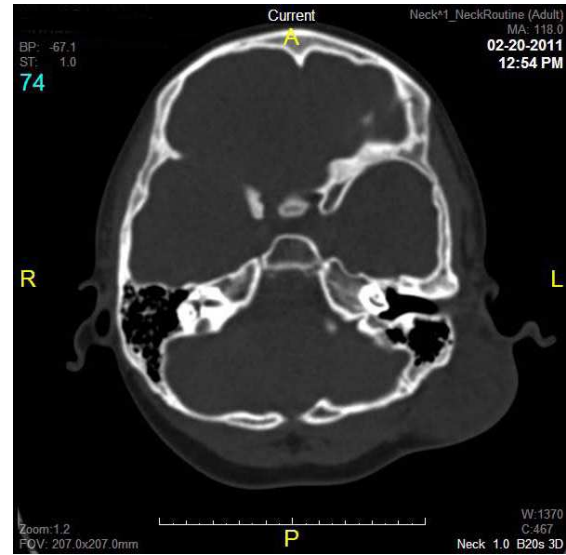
Axial view CT scan of neck shows a well defined heterogenous lesion at the left posterior auricular region.
